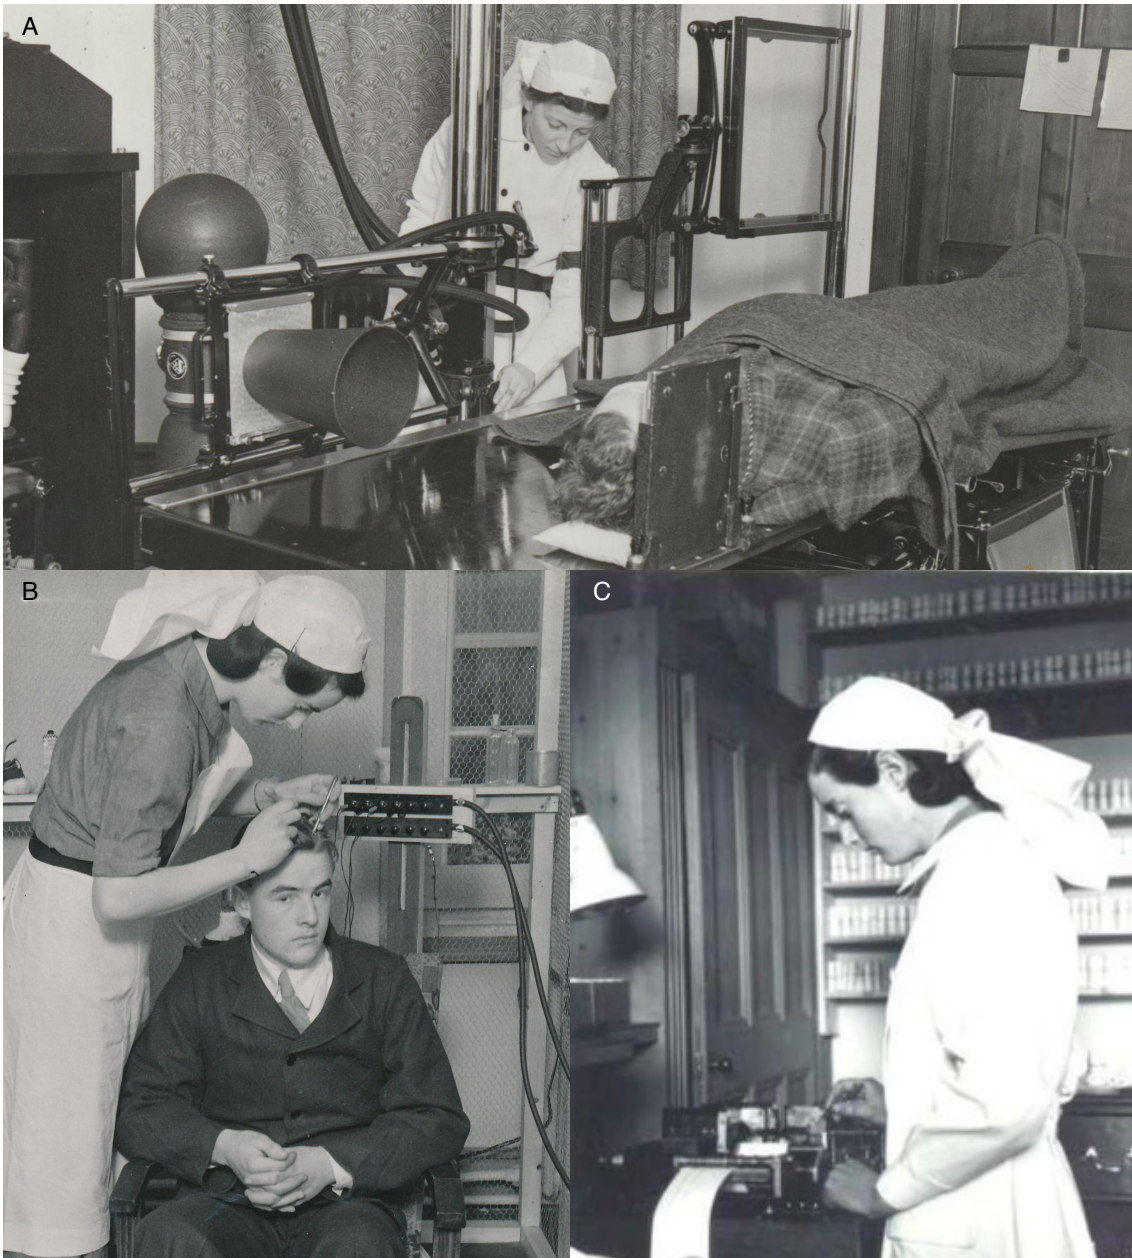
X-ray and electroencephalography (EEG) performed at the Military Hospital for Head Injuries. A. A lateral skull x-ray being acquired. B. EEG probes being applied to the scalp of a patient. C. An EEG tracing being printed. Photographs reproduced by kind permission of the Principal and Fellows of St Hugh's College, Oxford.
